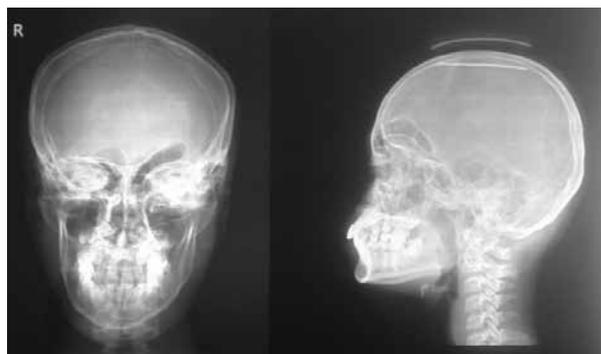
X-ray skull showing thickening of skull vault and enlargement of left frontal sinus also ethmoidal air cells.
